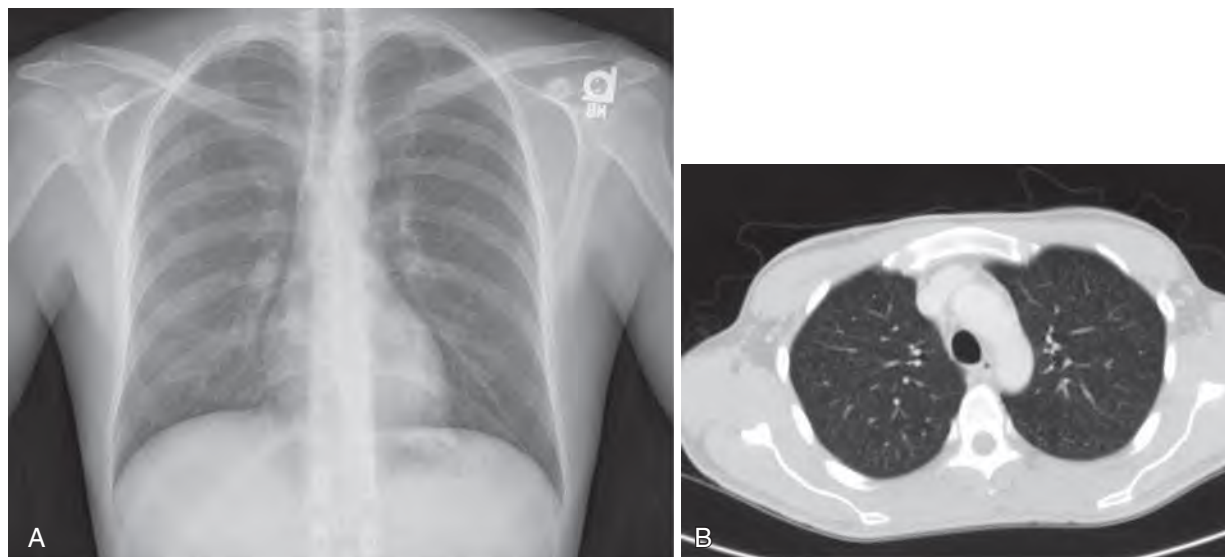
(A) 68-year-old with fever, cough, and 20-lb weight loss over the past 6 months. Routine chest radiograph reveals a classic miliary pattern. Transbronchial biopsy revealed granulomata without organisms; cultures were positive for *Mycobacterium tuberculosis*. (B) Chest computed tomography on this patient reveals diffuse interstitial nodular findings consistent with miliary tuberculosis.
